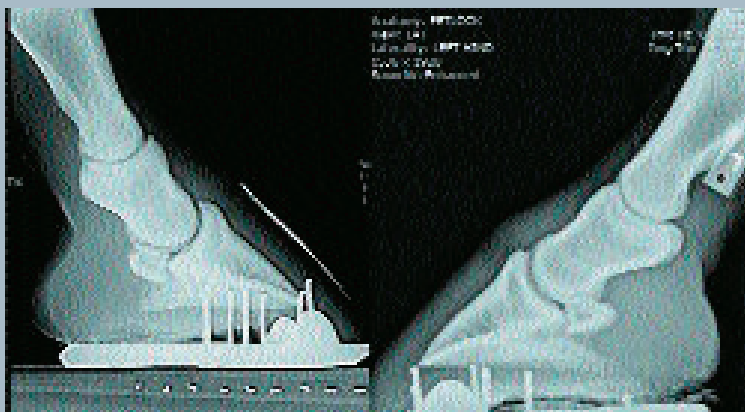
Note the position of P2 relative to P3 in both radiographs. This places the load on the palmar section of the foot.
